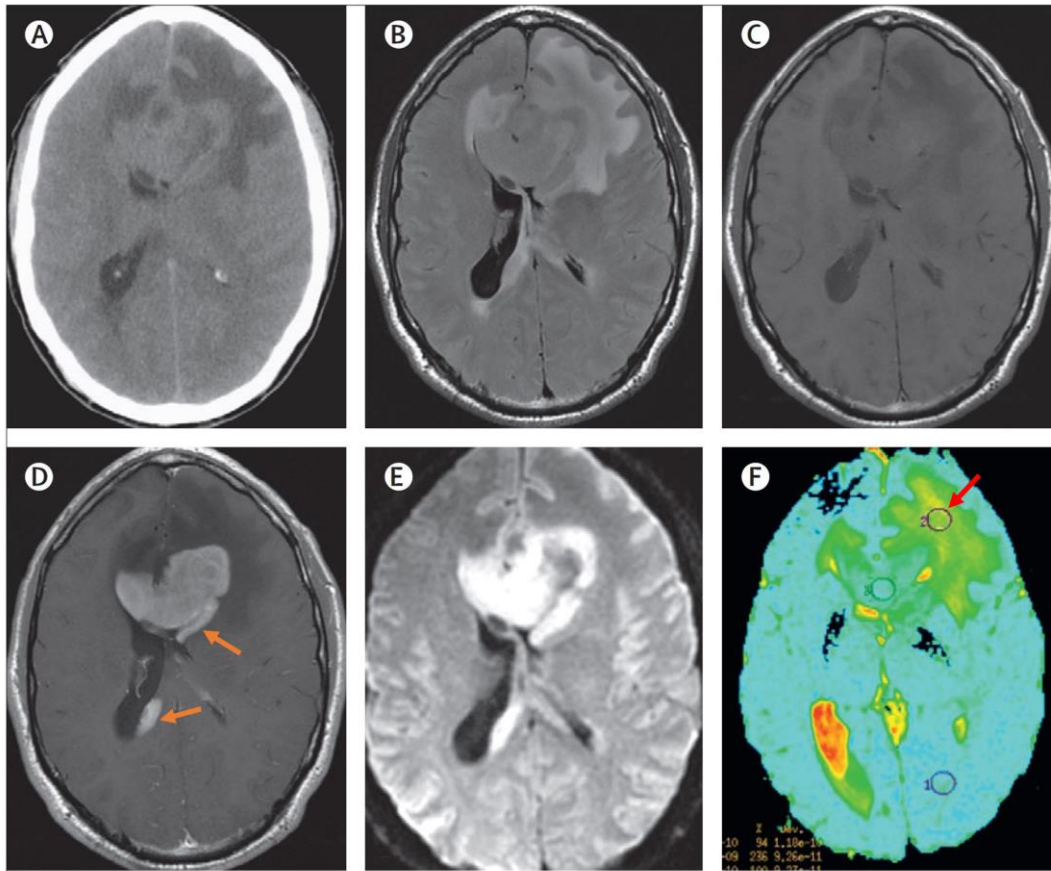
Multimodality medical imaging scan of the brain of a middle-aged man with a primary central neural system lymphoma (A) A CT scan shows a spontaneous mild hyperdense lesion. (B) A fluid attenuated inversion recovery (FLAIR)-weighted MRI of a peripheral oedema. (C and D) A T1-weighted spin-echo MRI without (C) and with (D) contrast with homogeneous enhancing of two lesions in contact with the ventricles. Contrast-enhanced T1w MRI provide high detectability of the tumor (see arrows) (E) A diffusion-weighted MRI with a high signal of the lesion. (F) An apparent diffusion coefficient map of a diffusion-weighted MRI that shows a restriction of intratumoral diffusion (see arrow), which is suggestive of a high cellular tumor. Reproduced from figure 7 in Ricard, D., Idbaih, A., Ducray, F., Lahutte, M., Hoang-Xuan, K., & Delattre, J. Y. (2012). Primary brain tumours in adults. *The Lancet*, 379(9830), 1984–1996.
